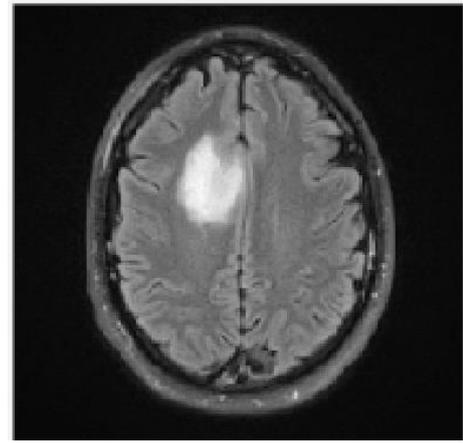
Series of malignant tumours in brain MR images (Input images).
